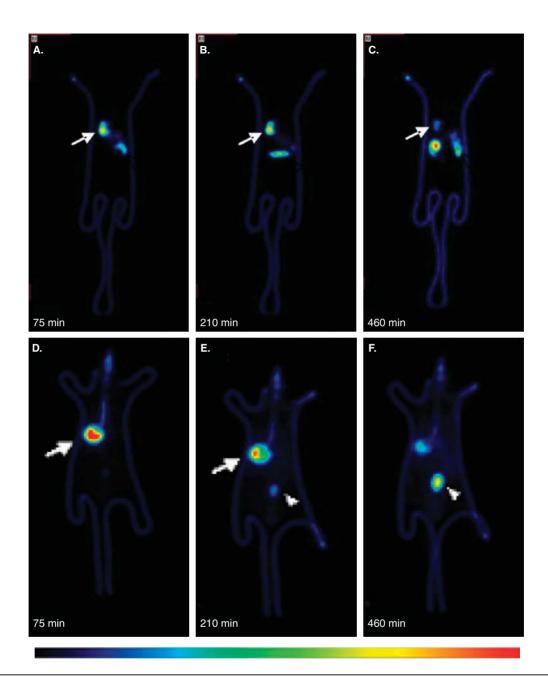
Comparison of the biodistribution of ^{99m}Tc-labeled, HPCD-NP (panels A - C) and a solution of ^{99m}Tc tetraoxygen $(^{99m}TcO_4^-)$ used as control (panels D - F). Panels A - C show scintigraphic images after oral administration of 10 mg of ^{99m}Tc-labeled HPCD-NP at 75, 210 and 480 min post-injection of anesthesia, respectively (arrow: stomach). Panels D – F show scintigraphic images after oral administration of 1 mCi of 99mTcO₄ solution at 75, 210 and 480 min post-injection of anesthesia, respectively (arrow: stomach; arrow head: bladder).
